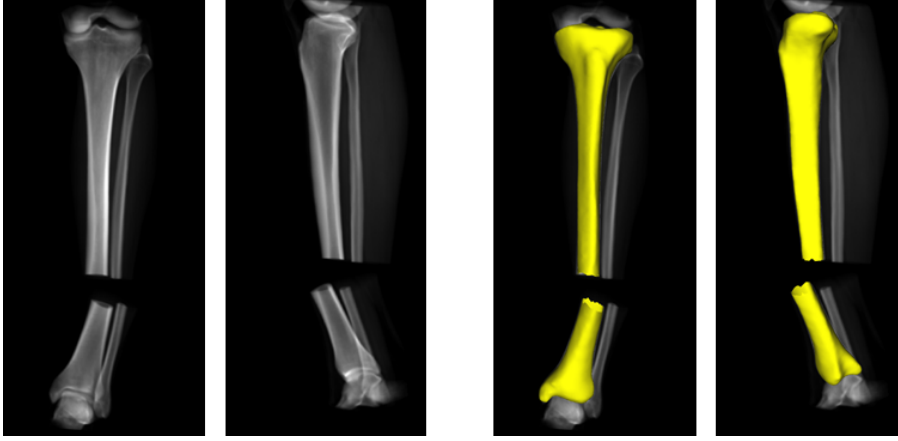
Set of digitally reconstructed radiographs (left) and with reconstructed fragments superimposed (right).
